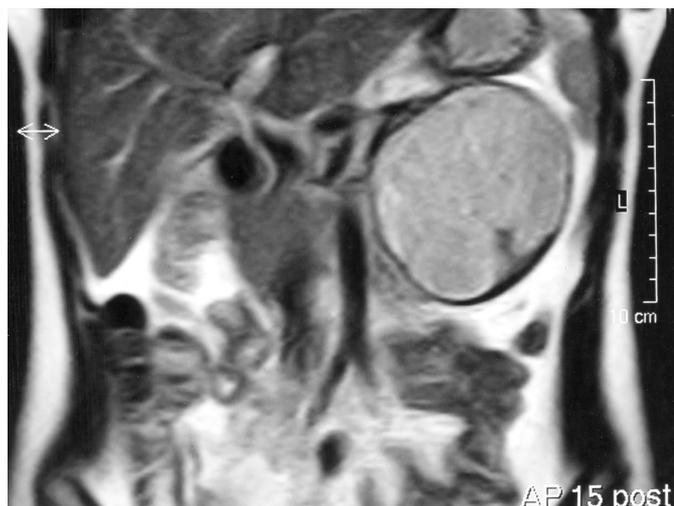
Magnetic Resonance Imaging showed a large (9 cm. in diameter), round, well encapsulated parenchymatous mass with calcifications and necrotic areas. The lesion abutted the posterior wall of the gastric body, adhered to and displaced the pancreatic body-tail and the splenic vessels.
